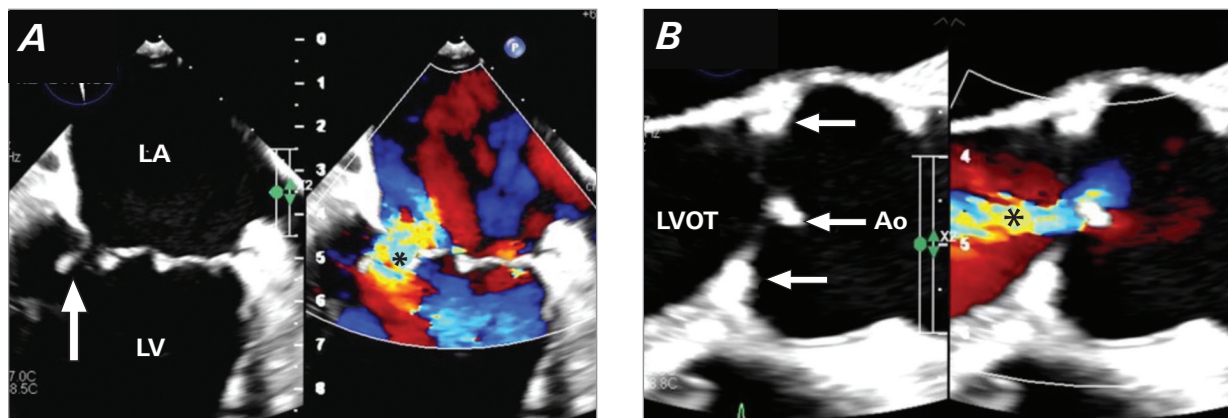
A) Intraoperative prebypass transesophageal echocardiogram without (left) and with Doppler technique (right). Midesophageal still frame in early systole (left) shows the posteromedial aspect of the posterior leaflet of the mitral valve (arrow), with evidence of postinflammatory changes, including thickening, retraction, and decreased mobility. These changes generate a jet of moderate to severe mitral valve regurgitation (right; asterisk). B) Intraoperative prebypass transesophageal echocardiogram without (left) and with Doppler technique (right). Midesophageal still frame of the aortic valve (left) shows thickening/calcification at the coaptation (central arrow) and at the bases of the cusps (upper and lower arrows), resulting in moderate central aortic valve regurgitant jet (right; asterisk).
